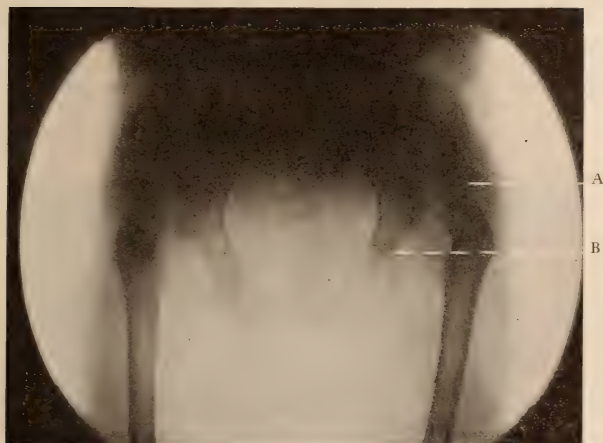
Roentgenogram before operation of hips of patient shown in Figs. 1, 2, 3, and 4. A, position of the dislocated head; B, acetabulum, the normal position of the head.
